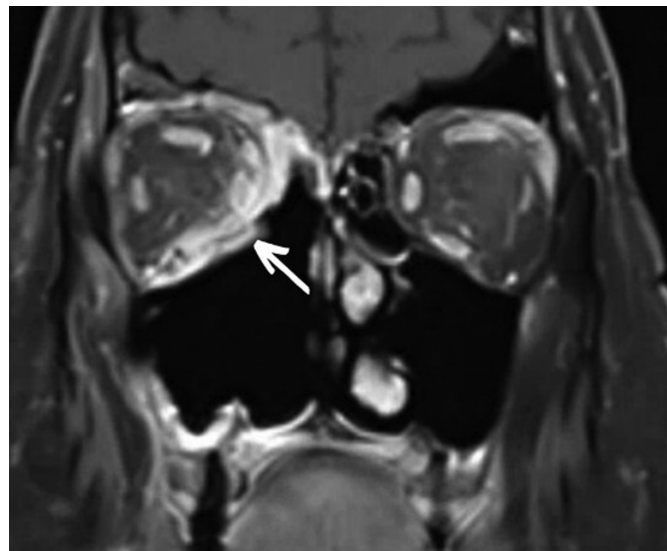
Contrast-enhanced T1-weighted magnetic resonance imaging after 3 retrobulbar amphotericin B injections.
